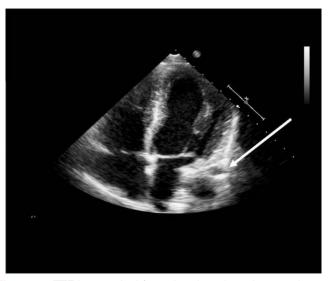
TTE in an apical four-chamber view. Arrow points to the left atrial appendage, which is herniated through a defect in a partial absence of the left pericardium. Video 29 (available at www.onlinejase.com) shows the same, along with excessive septal motion and angulation of the ventricular and atrial septum.
